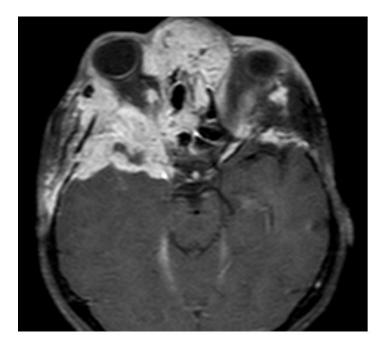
T1 weighted MRI with contrast shows that there were rapid progression of lesions in ethmoid sinus area and new formation of tumoral mass at lateral wall of the right orbit that leads expansion towards to the right temporal region
